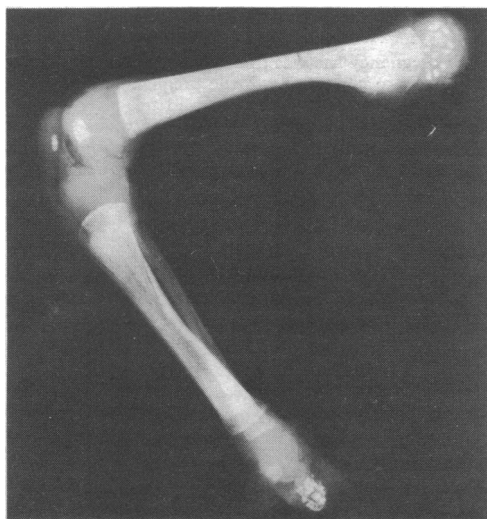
Postmortem radiograph showing punctate calcifications in epiphyses of the arm.
